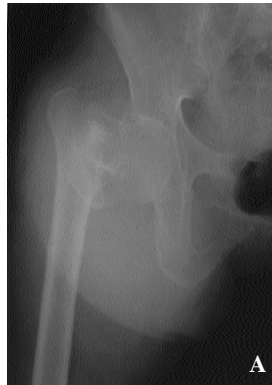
Preoperative roentgenogram of 65 years old female, Evans classification (comminuted) and Singh index .
